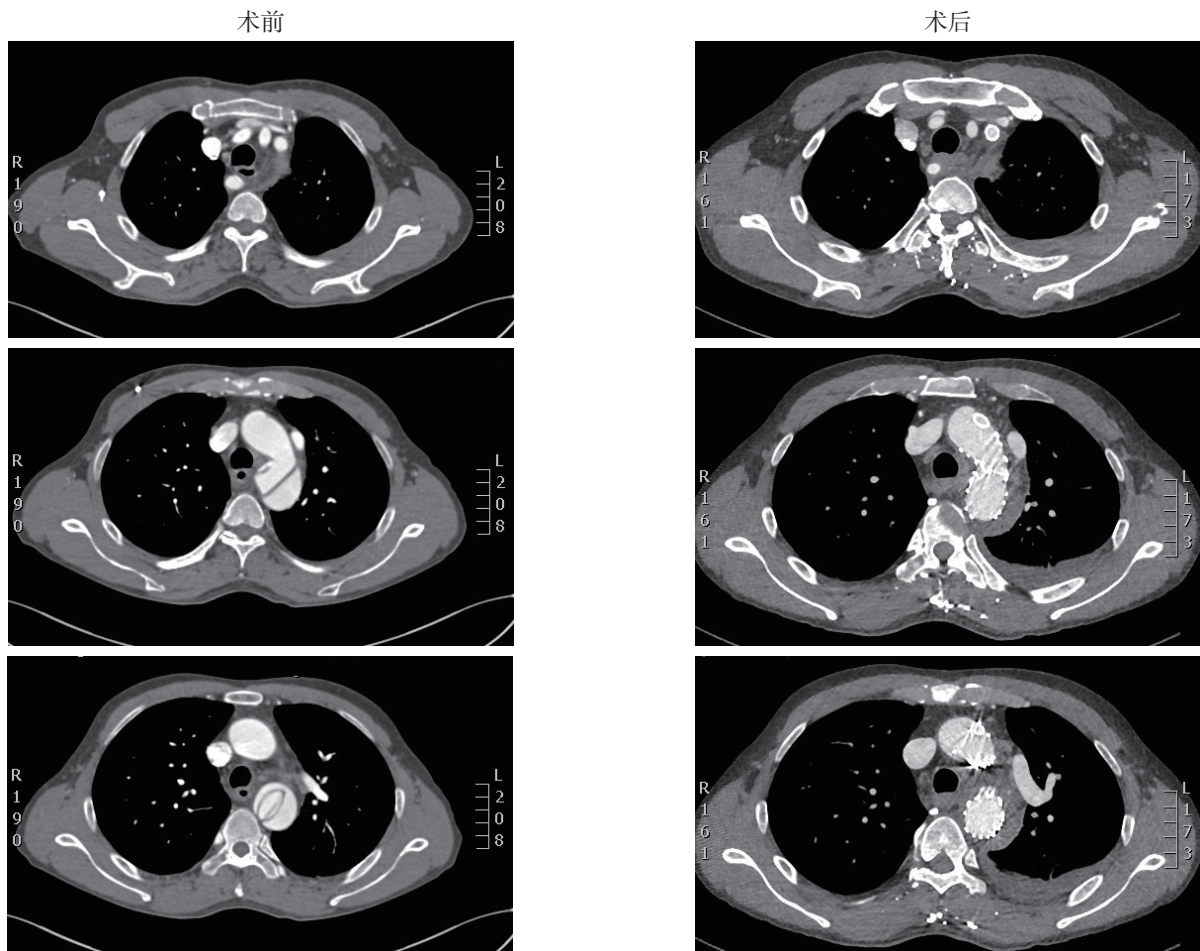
使用 TEVAR 联合烟囱技术重建 LSA 患者的 CTA 图像 (LSA 内烟囱支架通畅, TBAD 原发破口被主动脉支架封堵, 真腔扩大而假腔缩小)
